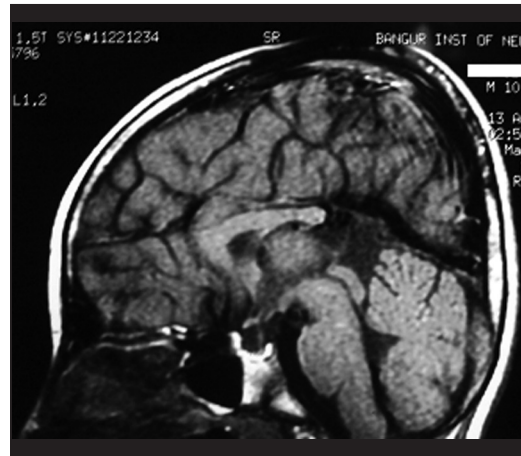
MRI brain showing hypoplastic pituitary with visible stalk and absent splenium of corpus callosum
